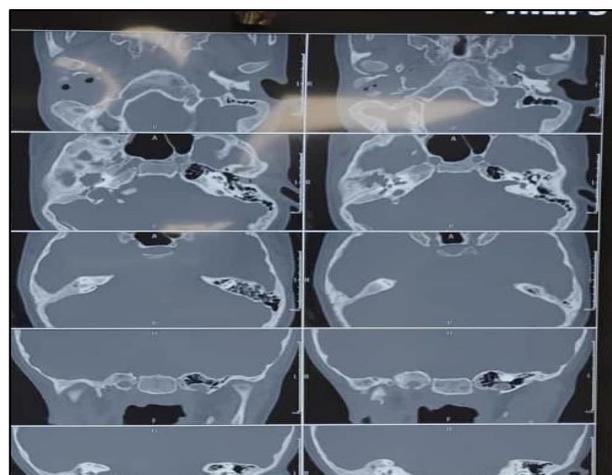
HRCT temporal bone showing right-sided otomastoiditis with congenital cholesteatoma and hypoplastic ossicles.
